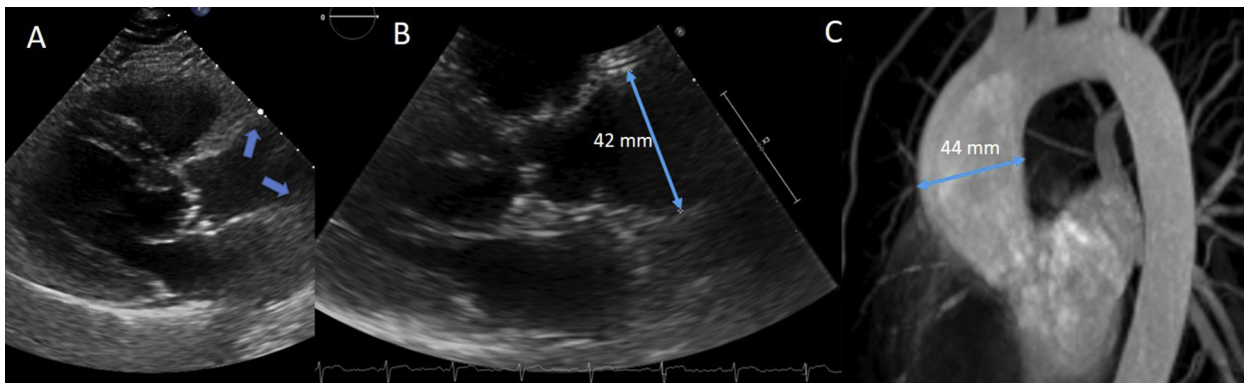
Representative multimodality aortic imaging in a competitive athlete with an ascending aortopathy. (A) Transthoracic echocardiographic parasternal long-axis view demonstrating possible proximal ascending aortic dilation (blue arrows). (B) Transthoracic echocardiographic parasternal long-axis view obtained one rib space higher demonstrating fusiform dilation of the ascending aorta. (C) Cardiac MR angiography imaging of the thoracic aorta demonstrating aneurysmal dilation confined to the ascending aorta.
